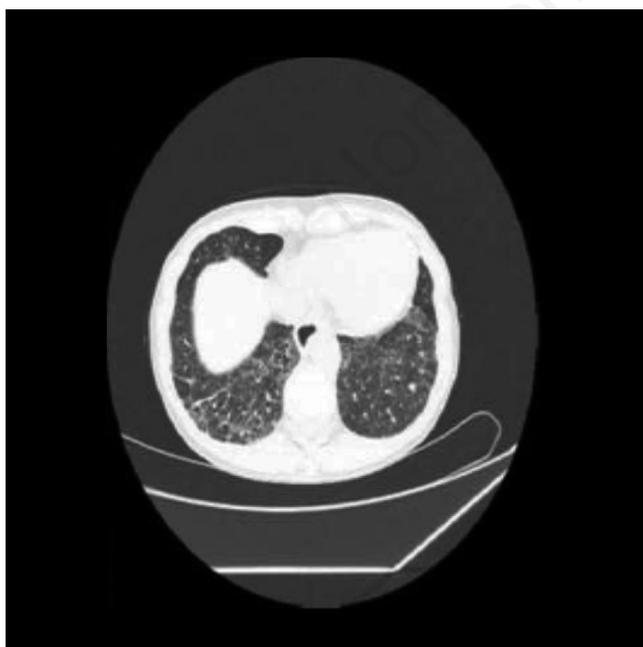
High-resolution computed tomography image suggesting nonspecific interstitial pneumonia. Note the ground glass areas at the lung bases bilaterally and thickening of the septa.
